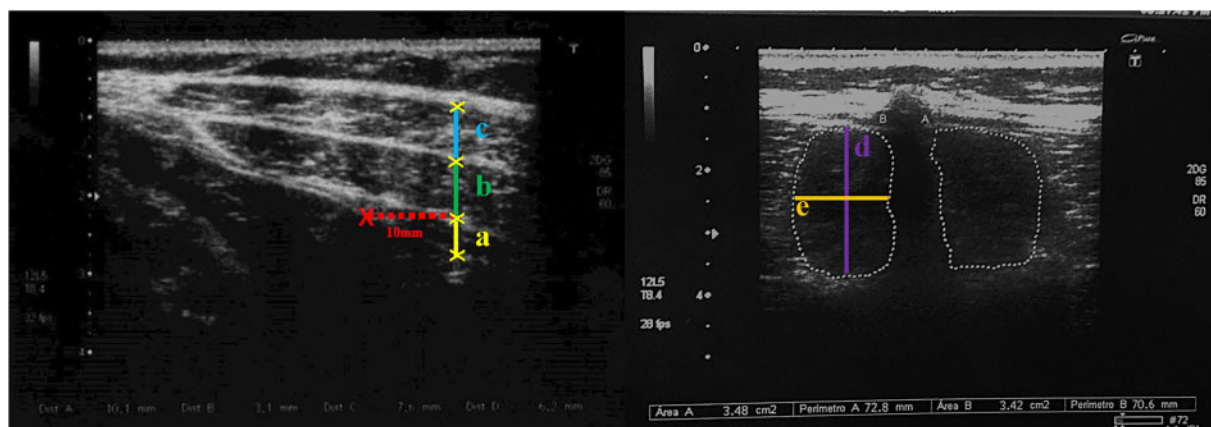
Ultrasound measurements of the abdominal wall (A) and the lumbar multifidus (B).
